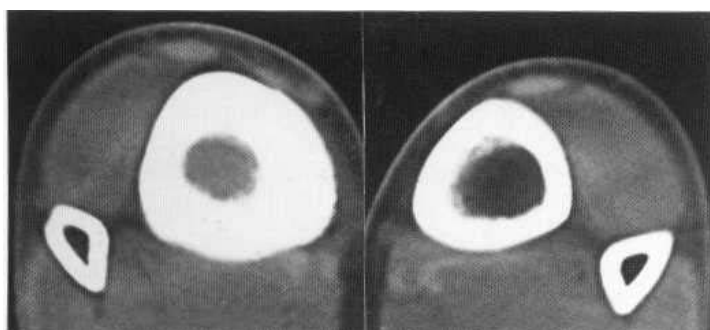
Chronic osteomyelitis. The CT scan shows the left side to be normal, while on the right there is extreme cortical thickening and marrow oedema of the tibia.
